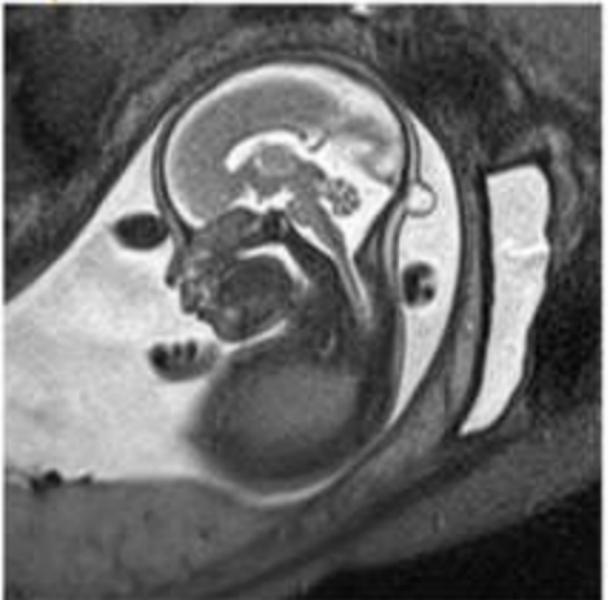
Small occipital encephalocele seen on intrauterine magnetic resonance imaging (MRI).
